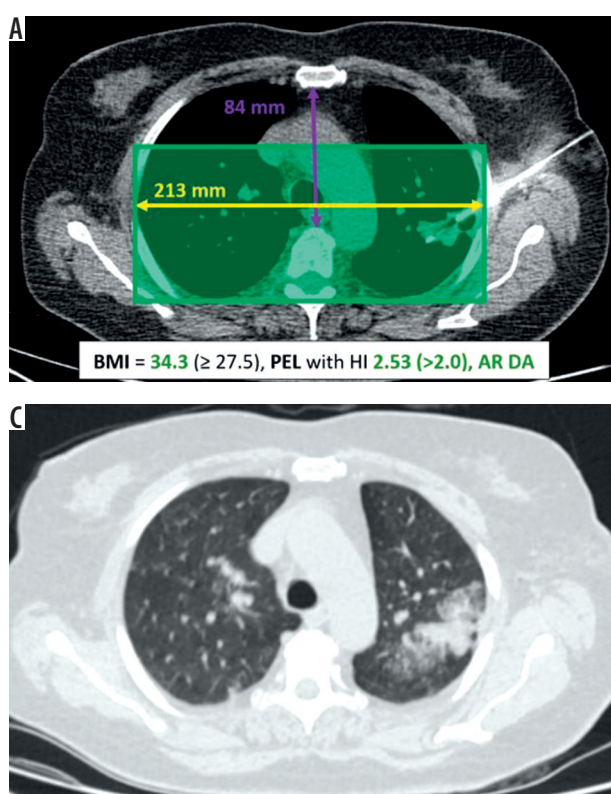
Optimal anatomical and positional conditions to minimize the risk of pneumothorax in CT-guided lung biopsies based on our findings. A) The target lesion in the apicoposterior segment of the left upper lobe is biopsied using a coaxial needle, with the access route positioned in the dependent area (highlighted in green according to our rule of thirds). Prerequisites: patient with grade I obesity and mild pectus excavatum at this level. B) At the level of the right inferior pulmonary vein, the thoracic shape exhibits an above-average T asymmetry. C) Post-biopsy, no pneumothorax is visible on the left side
